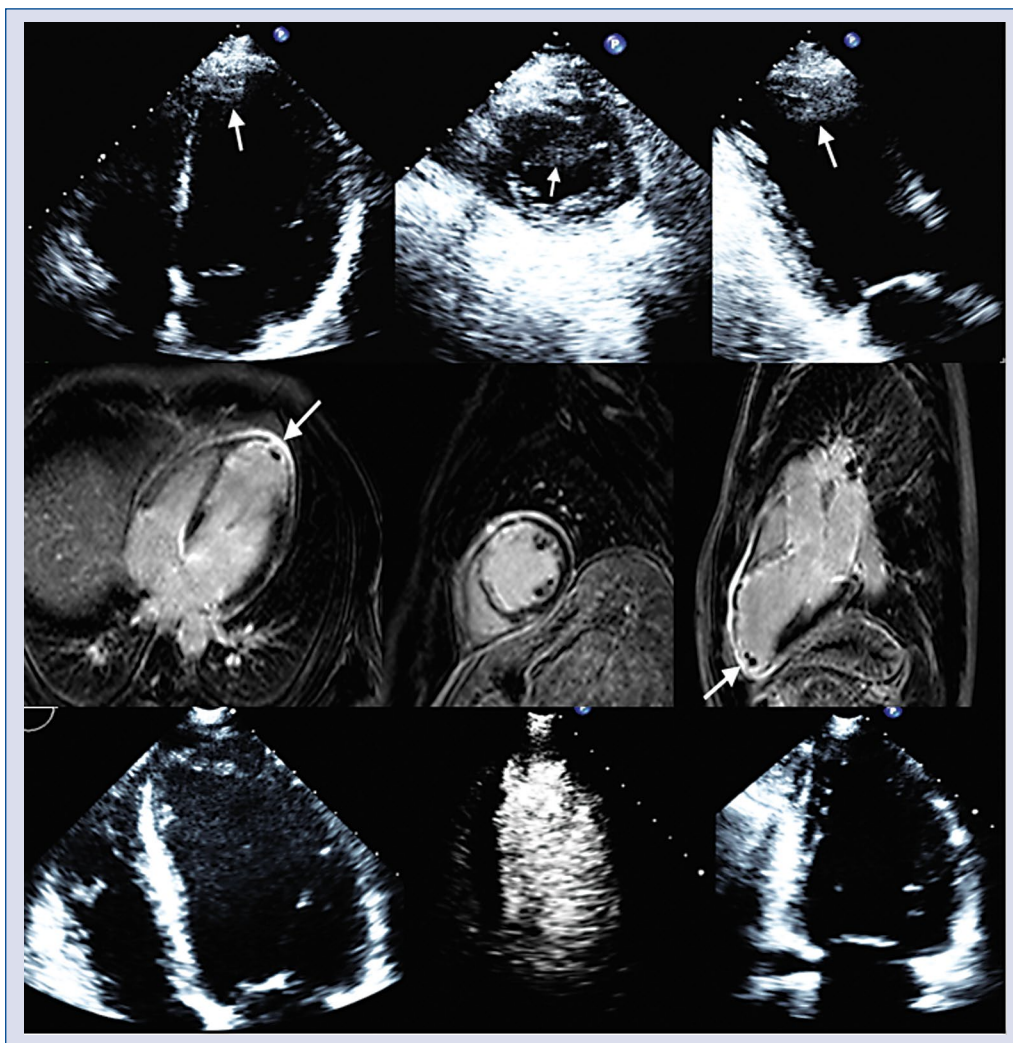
Evolution of left ventricular thrombus with vitamin K antagonists and with rivaroxaban treatment. Upper images: Transthoracic echocardiography revealed a fixed mural thrombus in the apex of the left ventricle after 2 months with anticoagulation treatment with vitamin K antagonists. Middle images: Cardiac magnetic resonance with late gadolinium enhancement imaging. The image on the left shows 4-chamber view with a mural thrombus adherent to left ventricular apex. Thrombus was easily identified as a low signal-intensity mass surrounded by high signal intensity structures in apex due to hyper-enhanced myocardial scar. The middle image shows short axis view with hyper-enhanced myocardial scar at septum and two images of ventricular thrombi. The image on the right shows the same with a 2-chamber view. Bottom images: Transthoracic echocardiography revealed complete thrombus resolution after 3 months of anticoagulant therapy with rivaroxaban.
